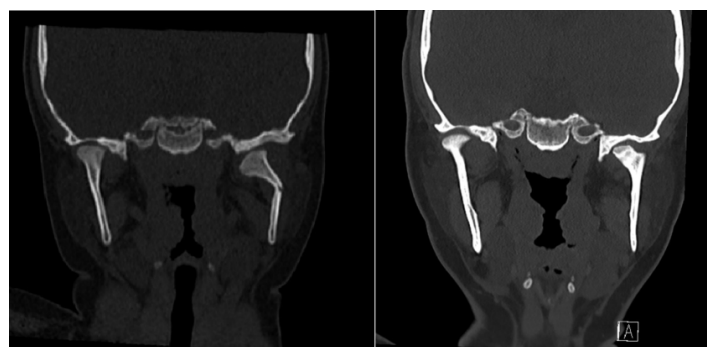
CT scan samples for excellent healing of a patients who had Arch Bars without ORIF
